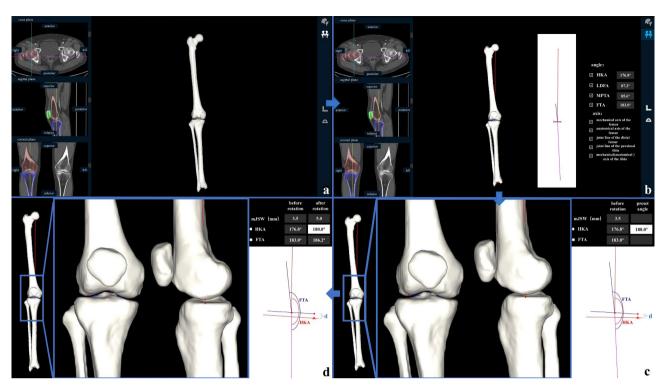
Usage steps of the full-length computed tomography (CT) software (a-d). (a) Step 1, import the full-length CT and segment the full-length CT of the target side by artificial intelligence method; (b) Step 2, manually mark the key points, automatically connect the axes and calculate the angles; (c) Step 3, manually preset the angle of hip–knee–ankle angle (HKA), and automatically display the original HKA, femoral tibial angle (FTA) and medial joint space width (mJSW); (d) Step 4, automatically rotate the tibia and fibula to the preset HKA and display HKA, FTA, and mJSW after rotation
